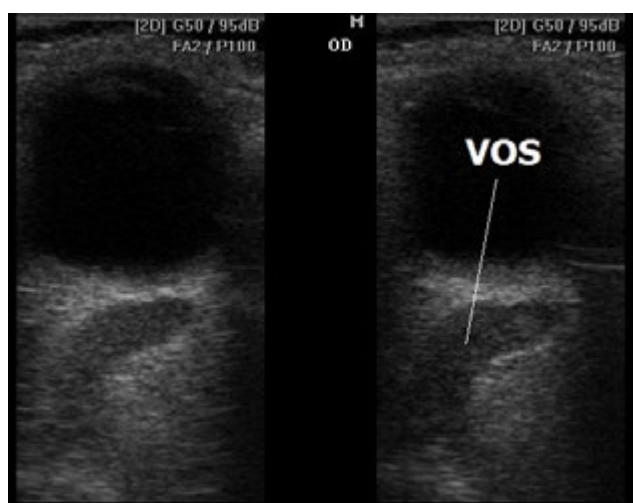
Dilatation of echo of superior ophthalmic vein (vena orbitalis superior – VOS) with the aid of ultrasonic B-scan upon carotid-cavernous fistula
